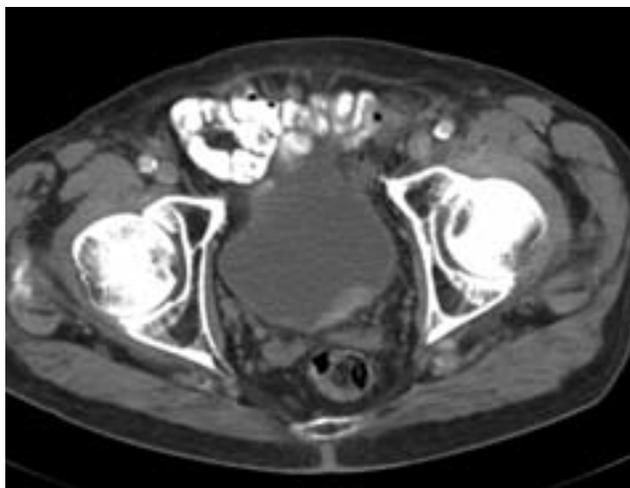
CT demonstrates an enhancing area of focal bladder wall thickening in the bladder base. Biopsy demonstrated transitional cell carcinoma.
